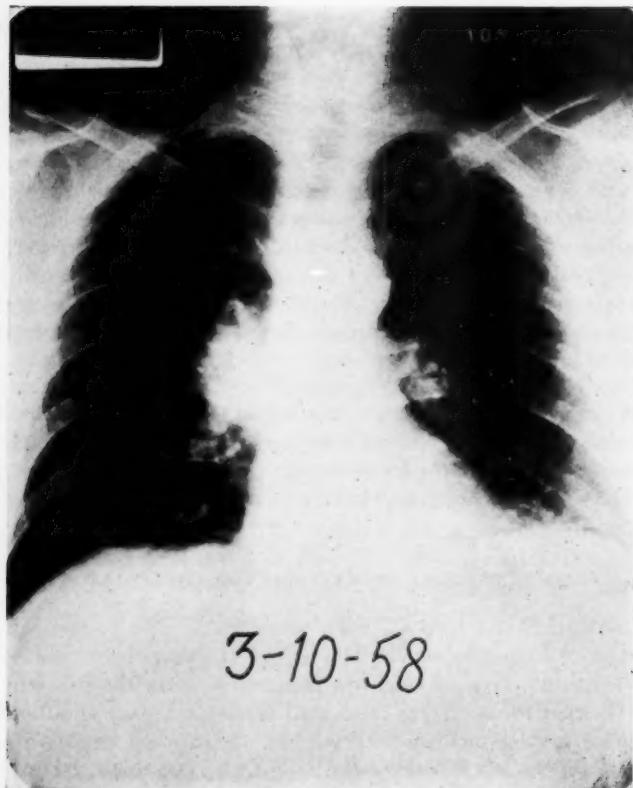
Case No. 1. Chest x-ray made on admission, showing large mass lesion in right hilum.
